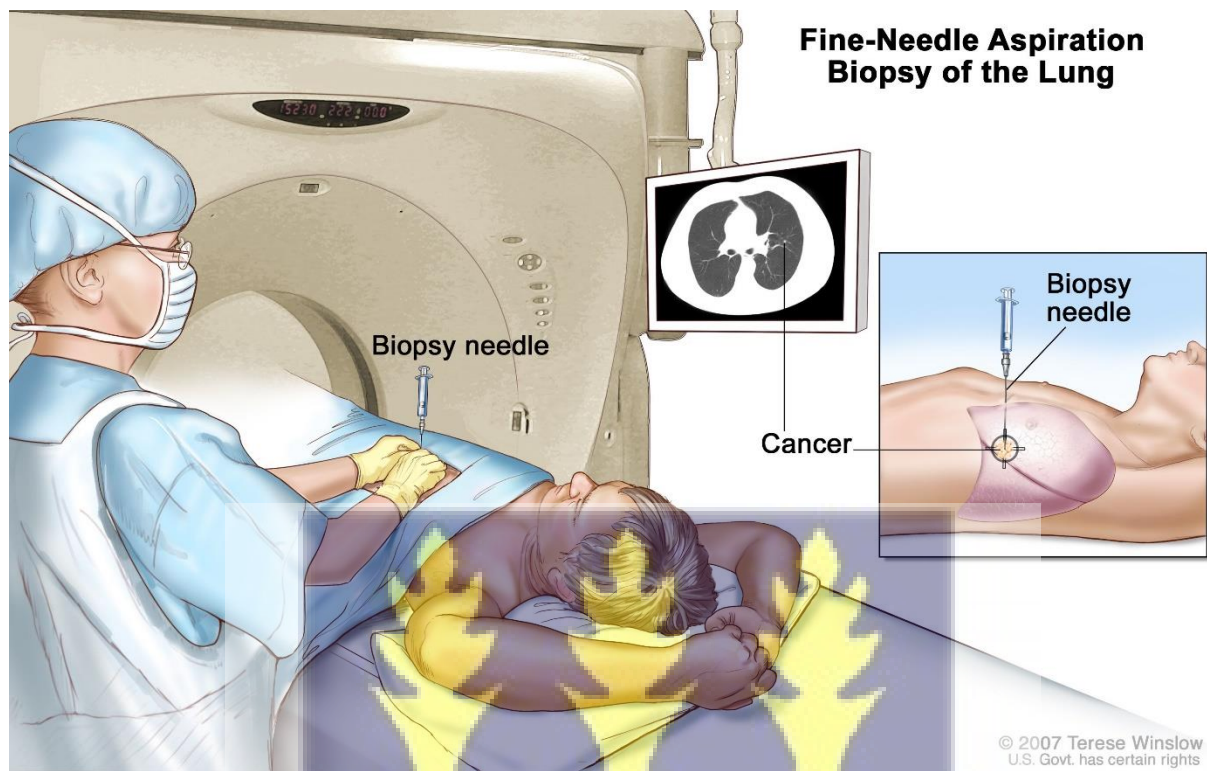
CT-guided biopsy (NCCN, 2021).
